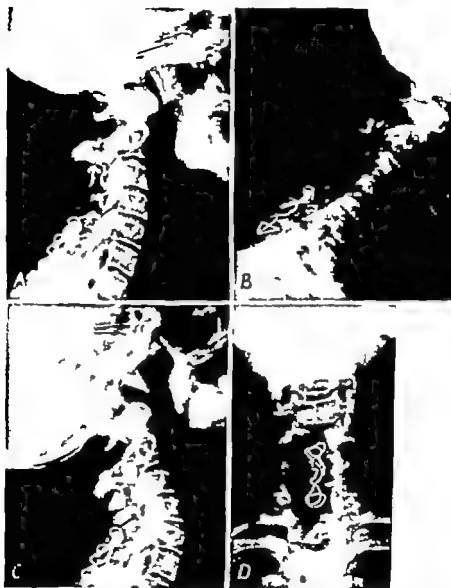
Radiographs of the cervical spine of a patient who first had symptoms of cervical nerve root irritation in 1950. After a short six days of traction failed to relieve the pain in her right shoulder and arm, the fifth, sixth and seventh vertebrae were fused. Several months later following myelographic studies, a "ruptured disc" was removed between the sixth and seventh vertebrae on the right side. Several months later the upper portion of the cervical spine was explored and screws were used across the joints for fixation. Eight months later the screws were removed and a cordotomy was done. In 1957 the patient still had irritation of the cervical nerve roots, plus a stiff neck and complete loss of sensation on the right side!
